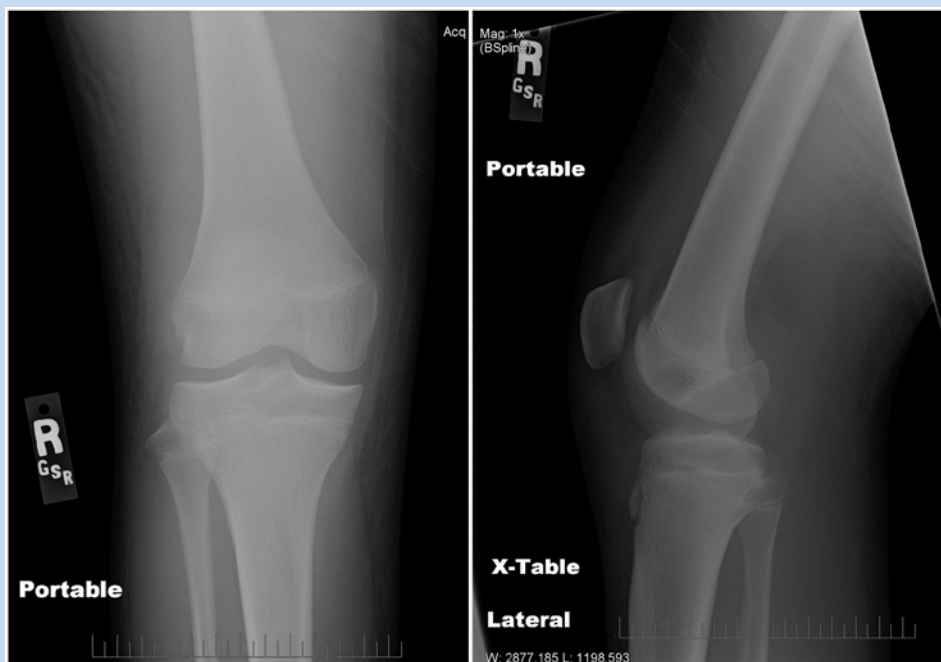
Antero-posterior (AP) and lateral radiographs of the affected right knee 3 days after closed injury. The AP view shows a congruent joint line, no interruptions of the subchondral or metaphyseal bone, regular physeal morphology, and normal tibiofemoral alignment. The lateral projection is slightly caudad without disruption of the tibial apophysis, the physeal line, or the posterior cortex through the physis. No significant effusion was present.
